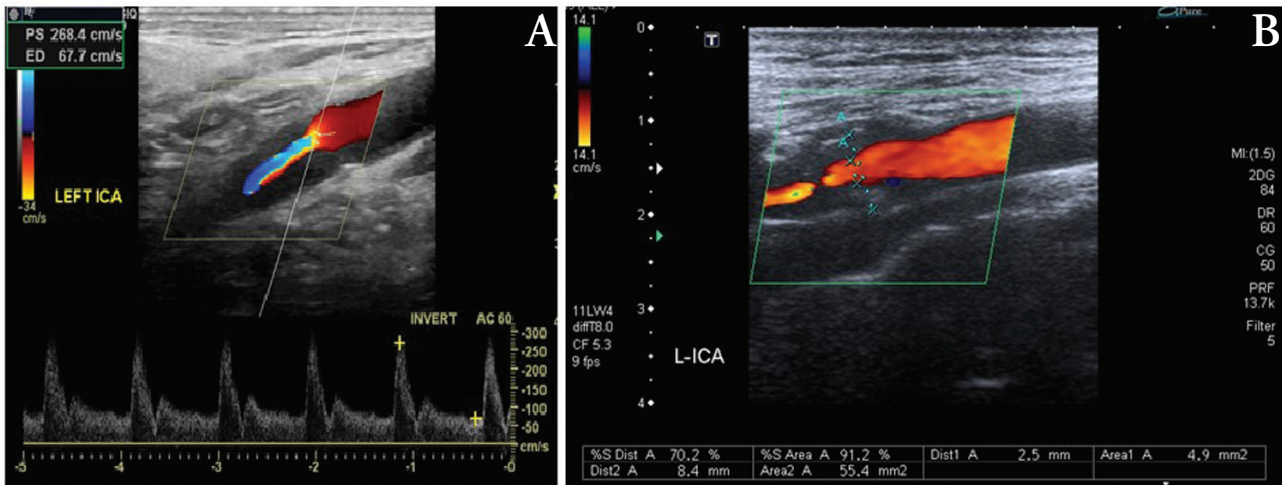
Duplex and color doppler images of a patient showing A) significant internal carotid artery (ICA) stenosis by velocity and B) degree of luminal stenosis by the European Carotid Surgery Trial (ESCT) method.
